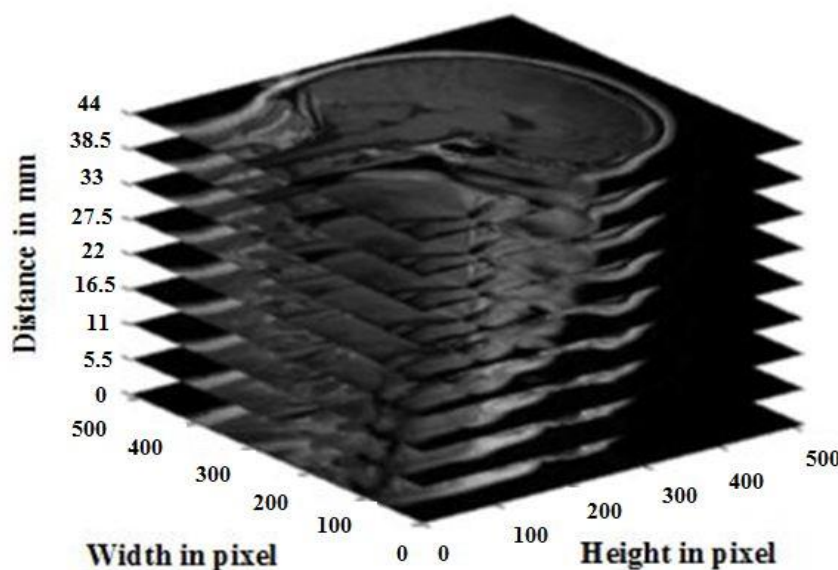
MR image sequence (Brown and Semelka 2011)
